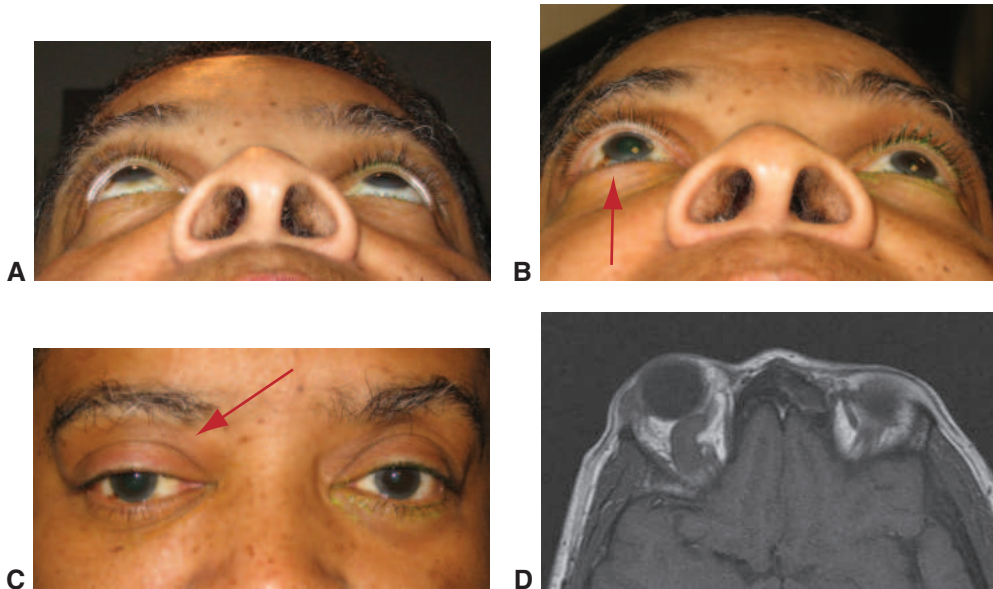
Distensible venous malformation. A, Mild proptosis resulting from venous malformation of the right orbit. B, After Valsalva maneuver, proptosis of the right globe increases (arrow). C, Fullness of the right superior orbit (arrow). Note the absence of dilated corkscrew conjunctival vessels. D, T1-weighted axial MRI shows a venous malformation of the superior ophthalmic vein. (Courtesy of Bobby S. Korn, MD, PhD.)
